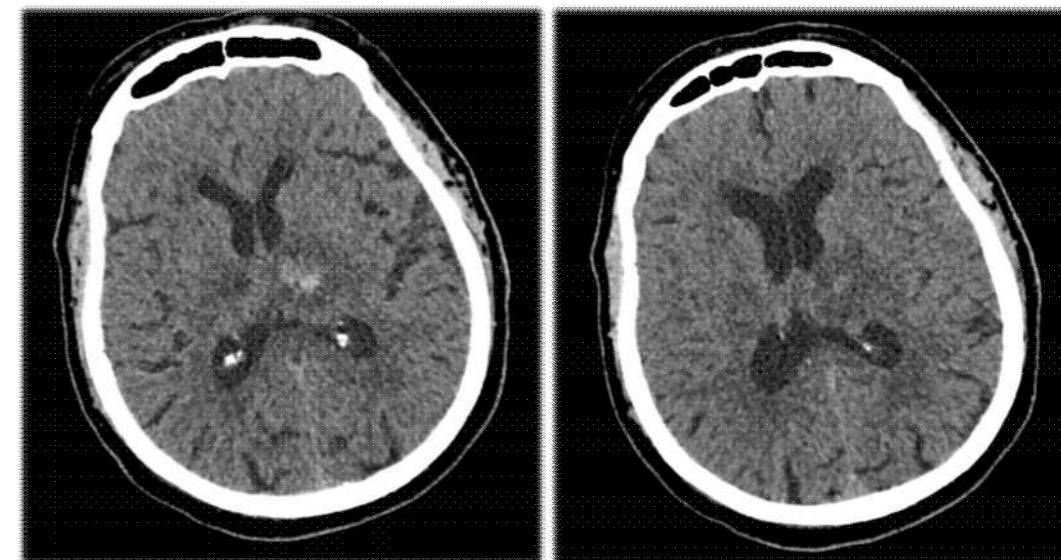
Head computed tomography (axial) performed on the day of admission was ischemic stroke in the basal ganglia (thalamus) bilaterally, with hemorrhagic transformation on the left.
